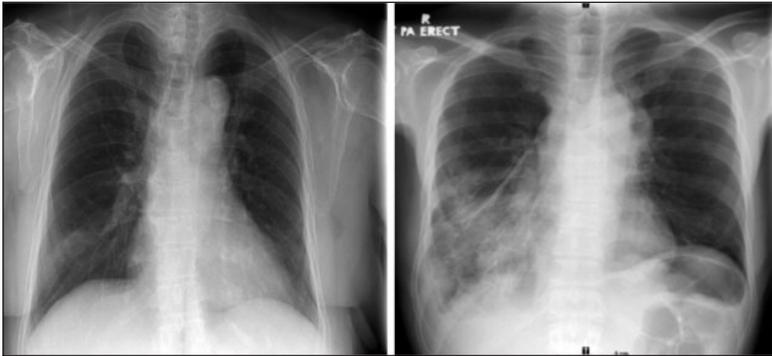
Normal Chest Radiograph (left) and Abnormal (right) chest radiograph
